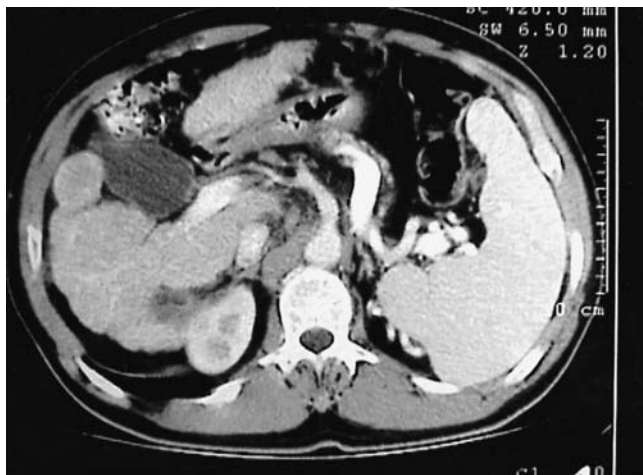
Helical-CT of protruding HCC in segment V, close to the gallbladder fundus
